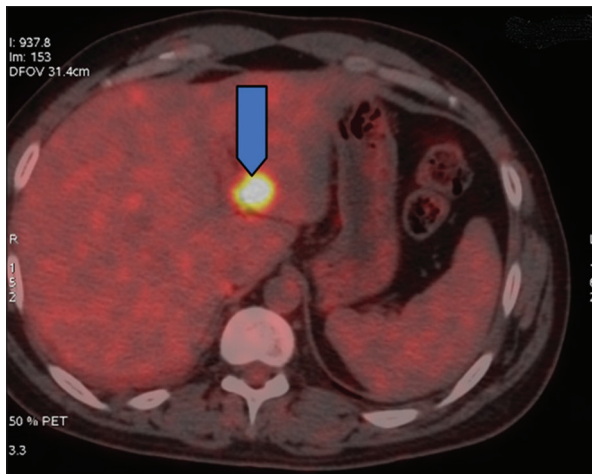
Positron emission tomography-computed tomography shows metabolically active lesion in the left lobe -liver metastasis
